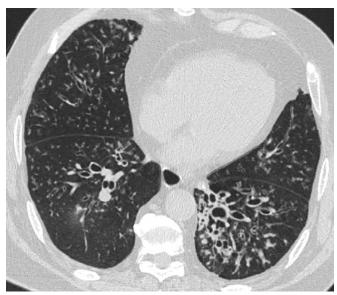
Computed tomography of the chest: cylindrical and cystic bronchiectasis.
